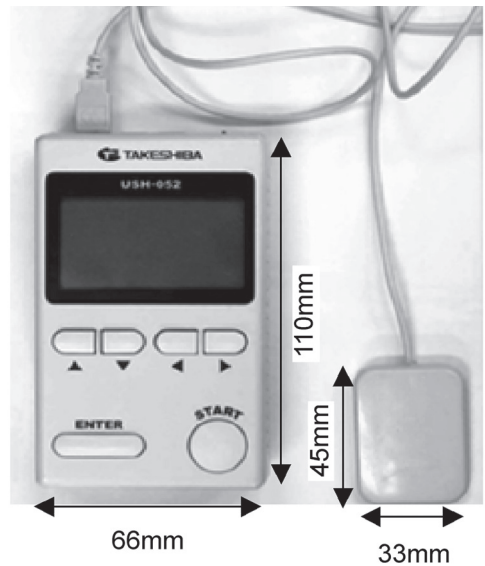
The commercially available ultrasonic urine sensor Yuririn USH-052⁹
